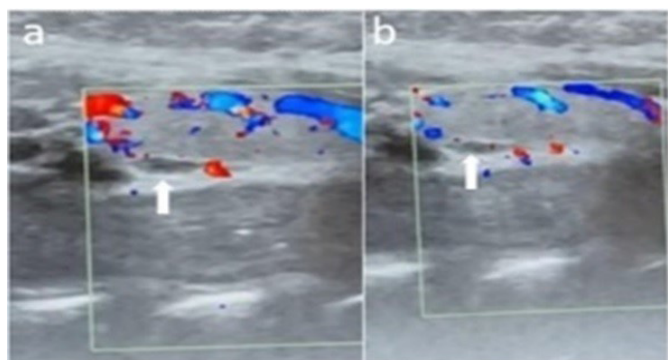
CDUS appearance of IET in a 6-year-old boy. Longitudinal plane ultrasound images of a patient with an incidental IET located in the posterior region of the left thyroid lobe (marked with white arrows)
